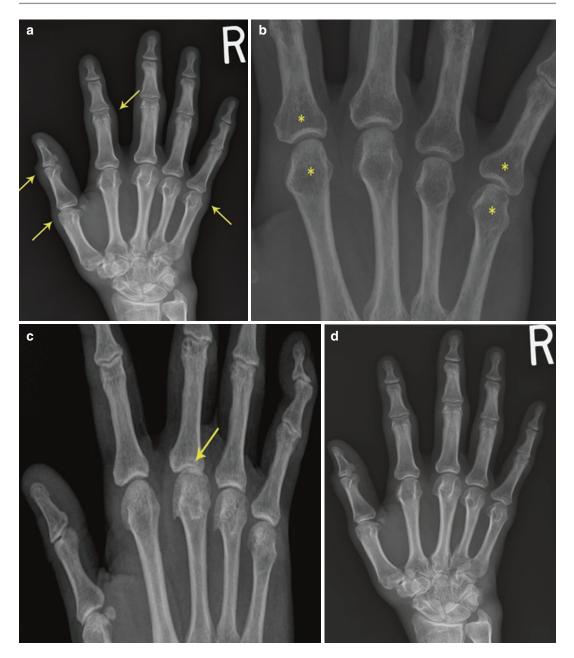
(a) Soft tissue swelling of the MCPJs and PIPJs (*arrows*). (b) Periarticular osteopenia (*asterisks*). (c) Joint space narrowing at 3rd MCP joint (*arrow*). (d) Normal R hand radiograph for comparison
